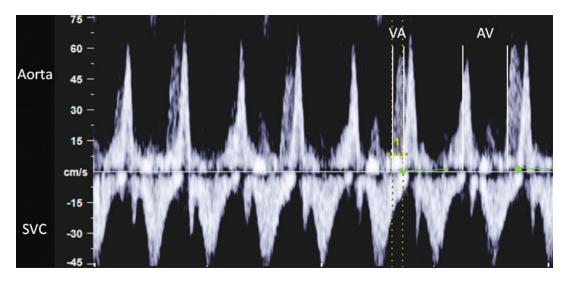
Doppler tracing obtained with the SVC/Ao method in a fetus with tachycardia. The VA interval is significantly shorter than the AV interval, suggesting a short VA tachycardia. Tall (cannon) "a" waves are
